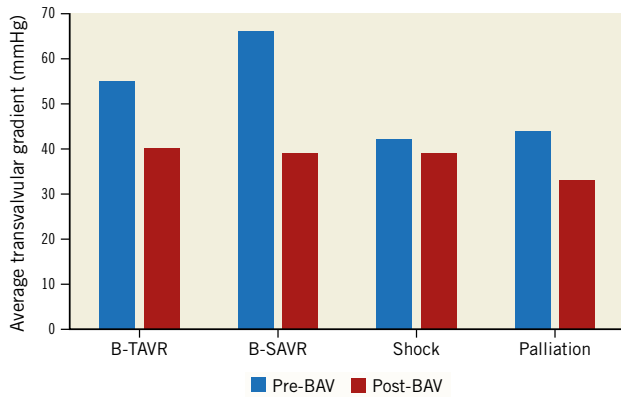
Average transvalvular gradient: echocardiographic assessment. BAV: balloon aortic valvuloplasty; B-SAVR: bridge to surgical aortic valve replacement; B-TAVR: bridge to transcatheter aortic valve replacement
